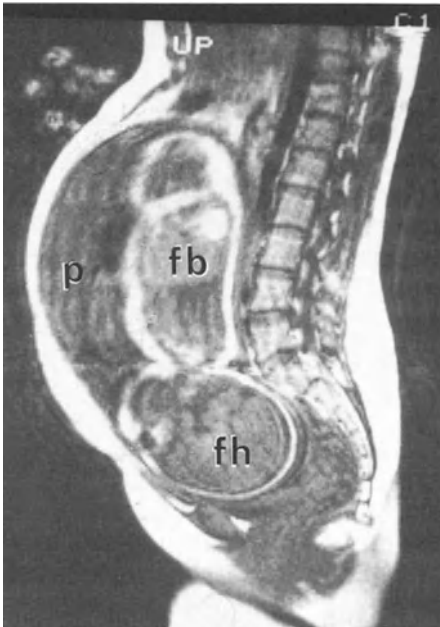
MRI: late pregnancy with fetal head and body well delineated. Placenta (*P*) located at the anterior wall of the uterus. *fh*, fetal head; *fb*, fetal body
